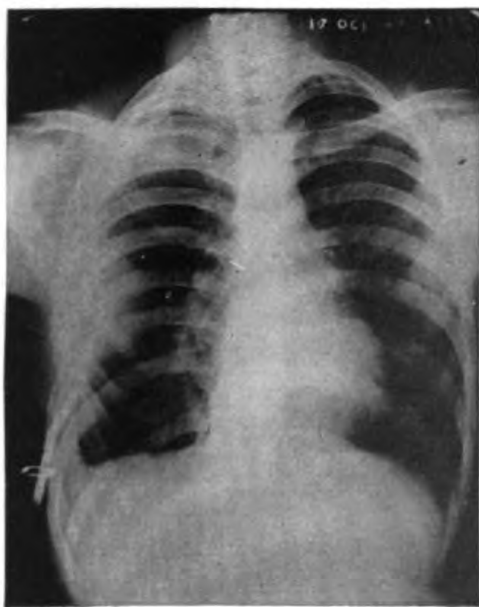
Case 6. Roentgenogram taken approximately 3 months after thoracostomy with drainage. This shows the residual cavity with the drainage tube in situ.
